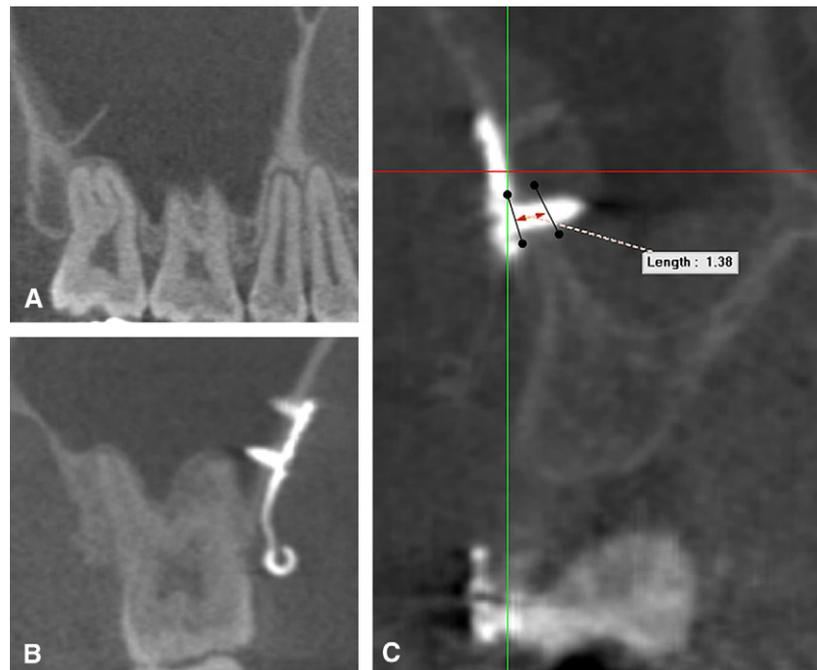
CBCT view of the miniplate showing sinus penetration of the miniscrew: A, sagittal view; B and C, frontal view.
